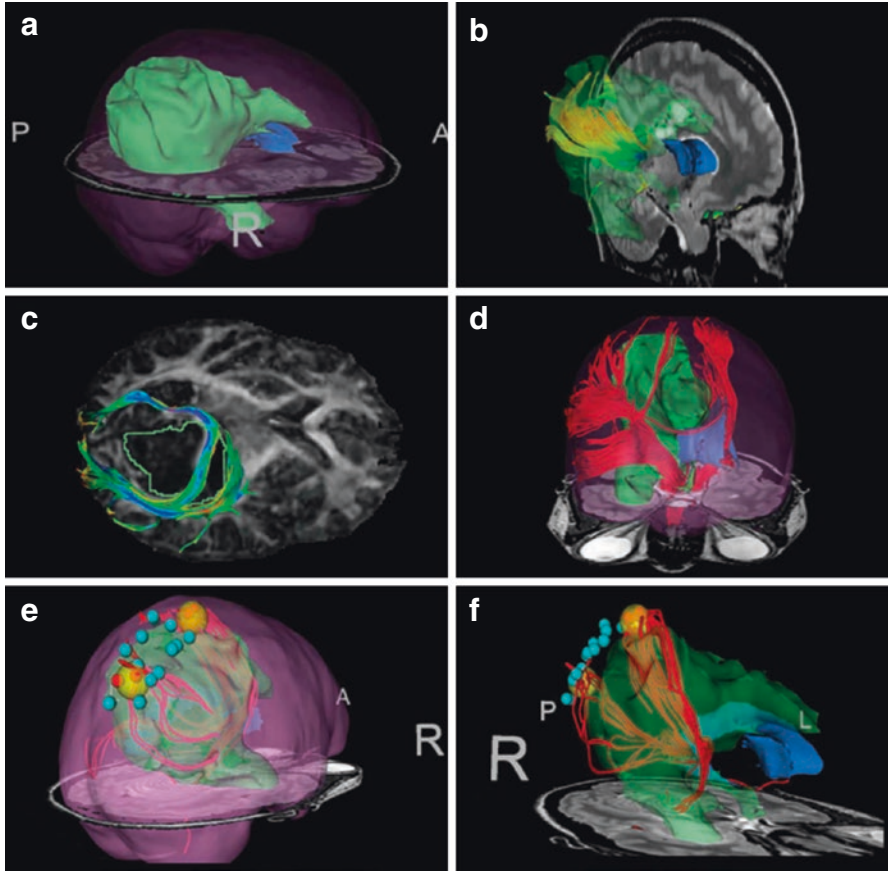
Multi-modal neurosurgical planning data on a large right fronto-parieto-occipital oligoastrocytoma WHO grade II. (a) 3D surface model of the tumor (*green*) with brain outline rendering (*pink*). (b) Tractography seeding within high-intensity T2-bright area demonstrates tracts within tumor region. (c) Manually seeded infiltrating and displaced tracts against the diffusion tensor imaging (DTI) fractional anisotropy map. (d) Region of interest seeding from cerebral peduncle to identify corticospinal tract. Seeding region was outlined on several T2-weighted slices, and tractography was seeded within this volume. (e) and (f), offline, postoperative tract seeding from intraoperative cortical stimulation locations (*red spheres*, positive). The *yellow spheres* represent enlarged seeding area around positive sites to seed DTI tracts that do not reach the cortical surface. (Source: [66])
